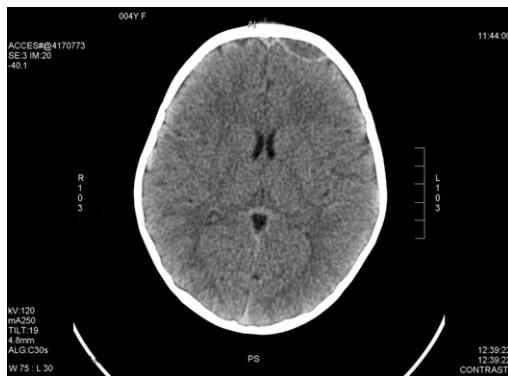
Computed tomography: epidural collection.
